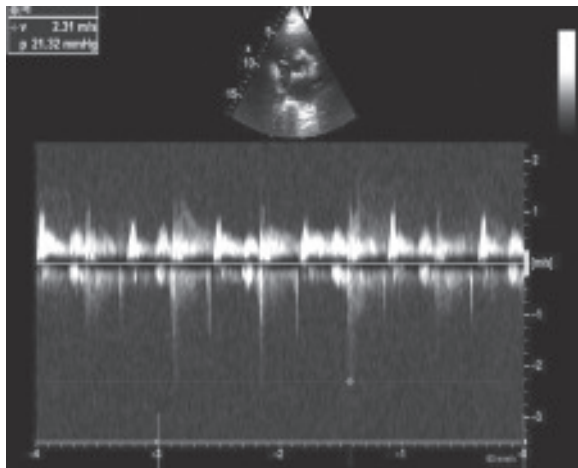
Colour Doppler echocardiography showed trivial tricuspid regurgitation*
